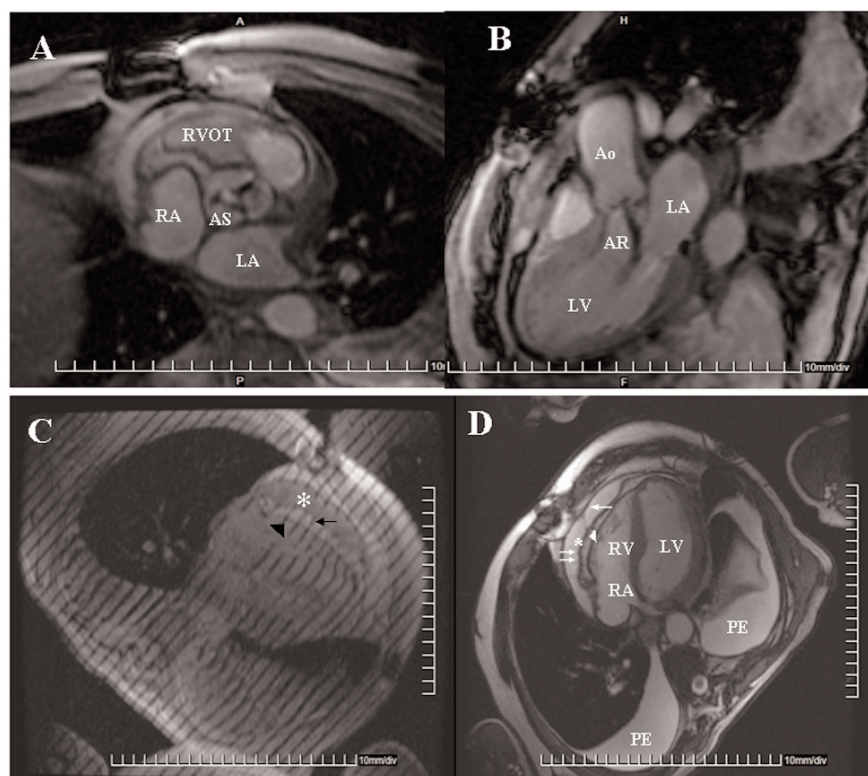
A, Mid-systolic gradient echo magnetic resonance image of the aortic valve showing moderate aortic stenosis (AS) with an aortic valve area of 1 cm^2 by planimetry. B, Gradient echo cardiac magnetic resonance image showing moderate aortic insufficiency (AI) in the left ventricular outflow view. C, Cardiac magnetic resonance image with tagging shows tethering of the pericardial layers (black arrow) to the myocardial surface of the right ventricular free wall (black arrowhead). D, Gradient echo steady state free precession cardiac magnetic resonance images in 3-chamber view in diastole showing a loculated pericardial effusion (*) predominantly over the right atrium and right ventricle measuring up to 2.8 cm in maximal dimensions with no evidence of tamponade. The visceral pericardium is thickened and measures up to 4 mm (double arrows). Also seen is the parietal pericardium (arrow), the sub-pericardial space (white arrowhead), and bilateral pleural effusions (PE). The inferior vena cava was dilated at 26 mm (not shown) and the left ventricular ejection fraction was 37%. RVOT indicates right ventricular outflow; RA, right atrium; LA, left atrium; Ao, aorta; LV, left ventricle.
